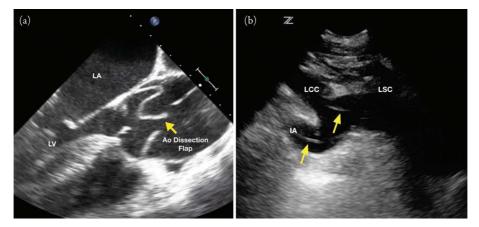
(a) Mid-esophageal long axis view using transesophageal echocardiography. Arrow points to ascending aorta dissection flap. LA = left atrium; LV = left ventricle. (b) Suprasternal view using transthoracic echocardiography. Arrows point to dissection flap going into the innominate artery and the left common carotid artery. IA = innominate artery; LCC = left common carotid artery; LSC = left subclavian artery.
